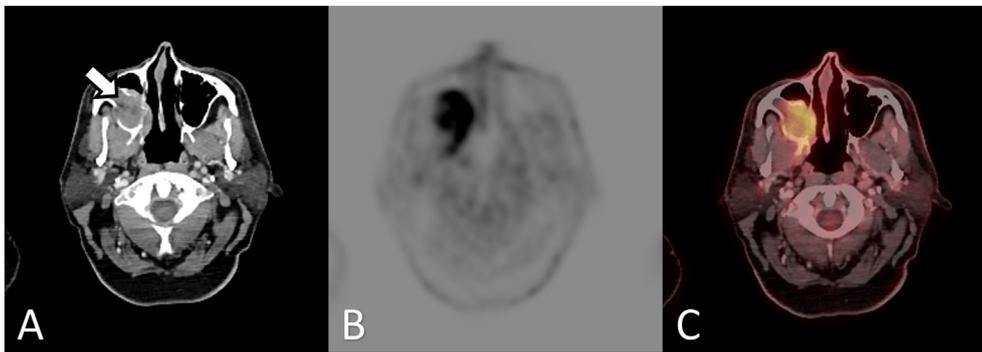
57 year old male with newly diagnosed maxillary sinus mass (A). Mass centered in the right maxillary sinus causes erosion of the lateral sinus osseous wall and extends to the retromaxillary fat pad. ^{18}F -FDG PET image demonstrates hypermetabolism ($\text{SUV}_{\text{max}} = 10.1$) in the region of the right maxillary sinus (B). FDG uptake extends posteriorly to involve the pterygoid plate and medially into the right posterior nasal cavity. Fused ^{18}F -FDG PET/CT images demonstrate the ^{18}F -FDG avidity of the maxillary sinus mass (C).
